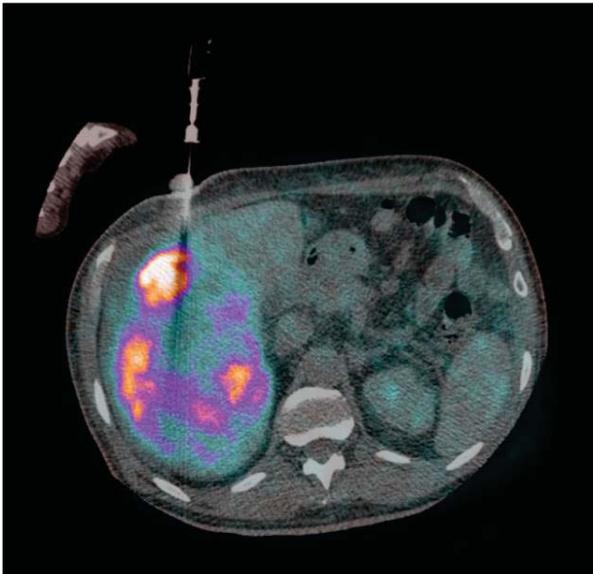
PET/CT guided needle intervention into highly metabolic area inside the lesion
